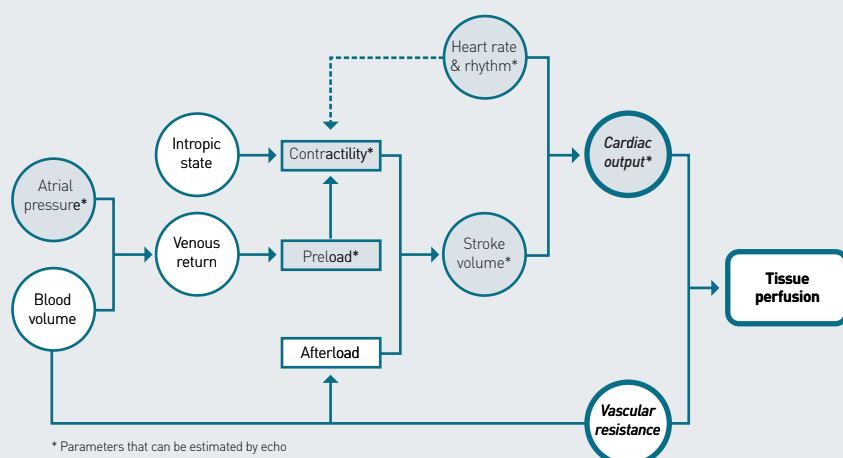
Haemodynamic Parameters Measured by Echocardiography
